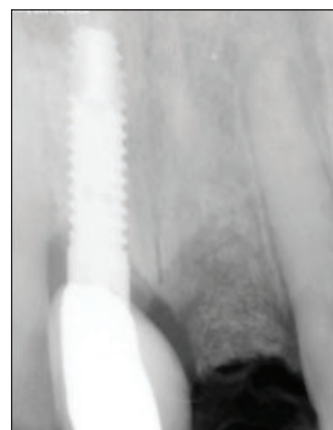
An immediate postop radiograph demonstrates the extraction site with FDB (MinerOss) in situ.
